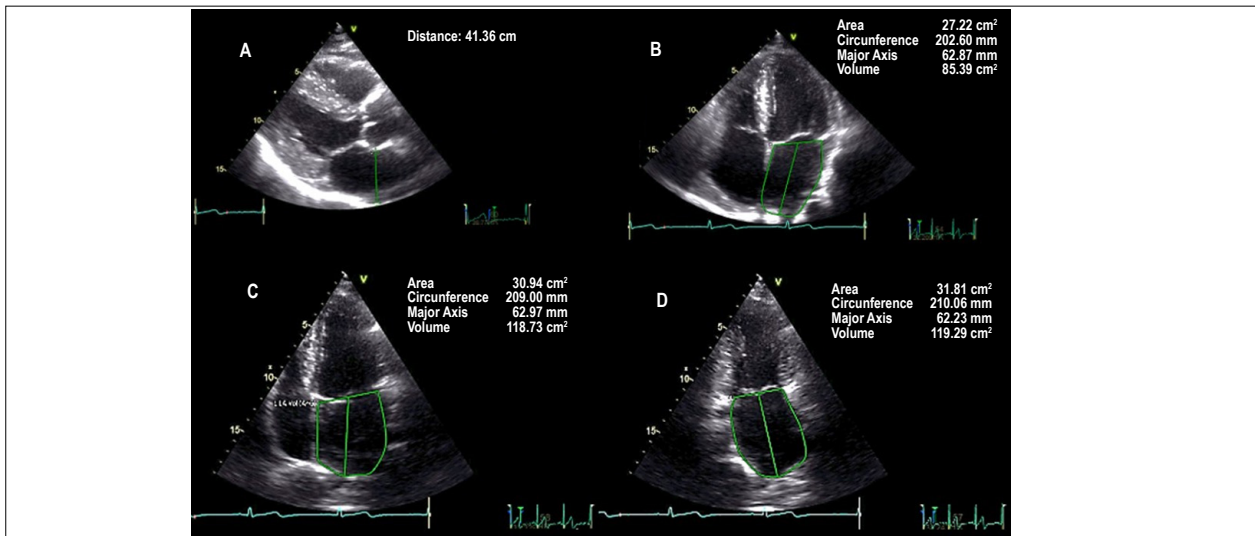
The left atrium is seen in the parasternal long-axis view (A), apical four chamber non-focused view (B) and LA focused four- (C) and two chamber views (D). When viewing the images side by side the underestimation of the antero-posterior diameter becomes apparent. The LA remodeling is constricted in the antero-posterior dimension because of the spine and sternum. The underestimation is greater when the LA is assessed in the LV focused view.
